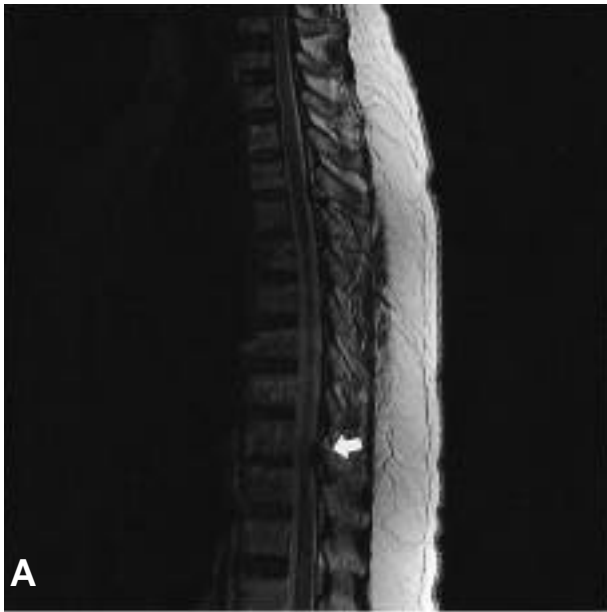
Magnetic resonance imaging of thoracic spine, sagittal T2-weighted image at the level of T9-T10, a round hypointense lesion occupying the posterior part of the spinal canal. B. Magnetic resonance imaging, axial T2-weighted image at T9-10 level, stenosis of spinal canal due to ossification of the ligamentum flavum can be seen.
